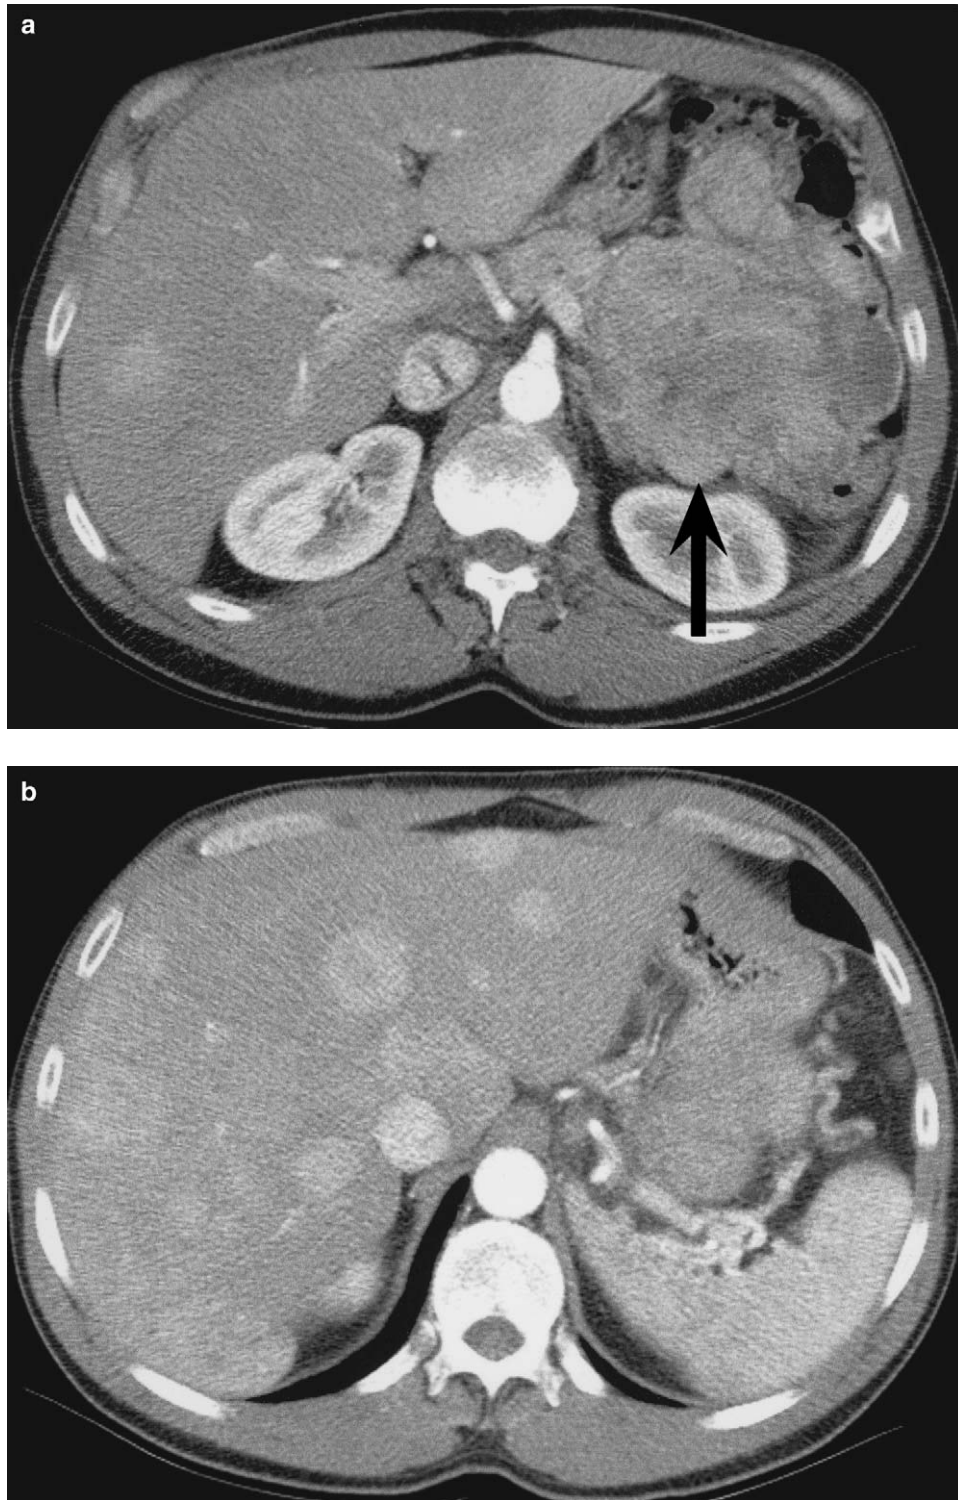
(a) Abdominal computed tomography scan with lobular mass in the tail of the pancreas involving the greater curvature of the stomach and invading the splenic vein. (b) Abdominal computed tomography scan with numerous hypervascular masses throughout the liver.
